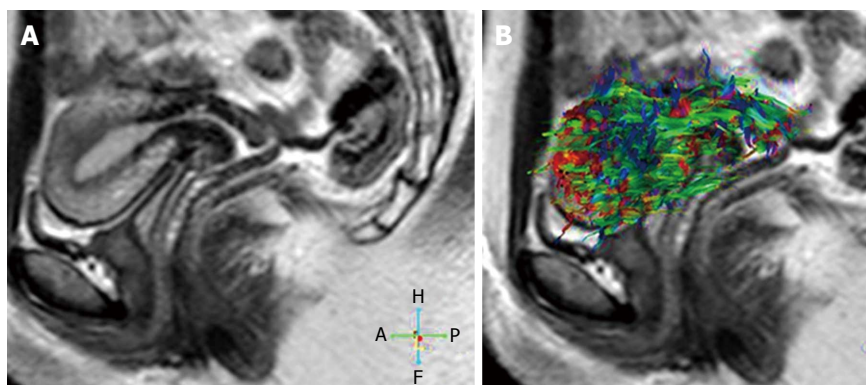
Thirty two years old volunteer. A: Sagittal T2-weighted image of a normal uterus; B: 3D whole tractography image of the normal uterus. Red colors represent a right-left orientation, blue represents a cranio-caudal orientation and green represents an antero-posterior orientation of diffusion. Changes in the intensity of the color represent different strengths of anisotropy.
